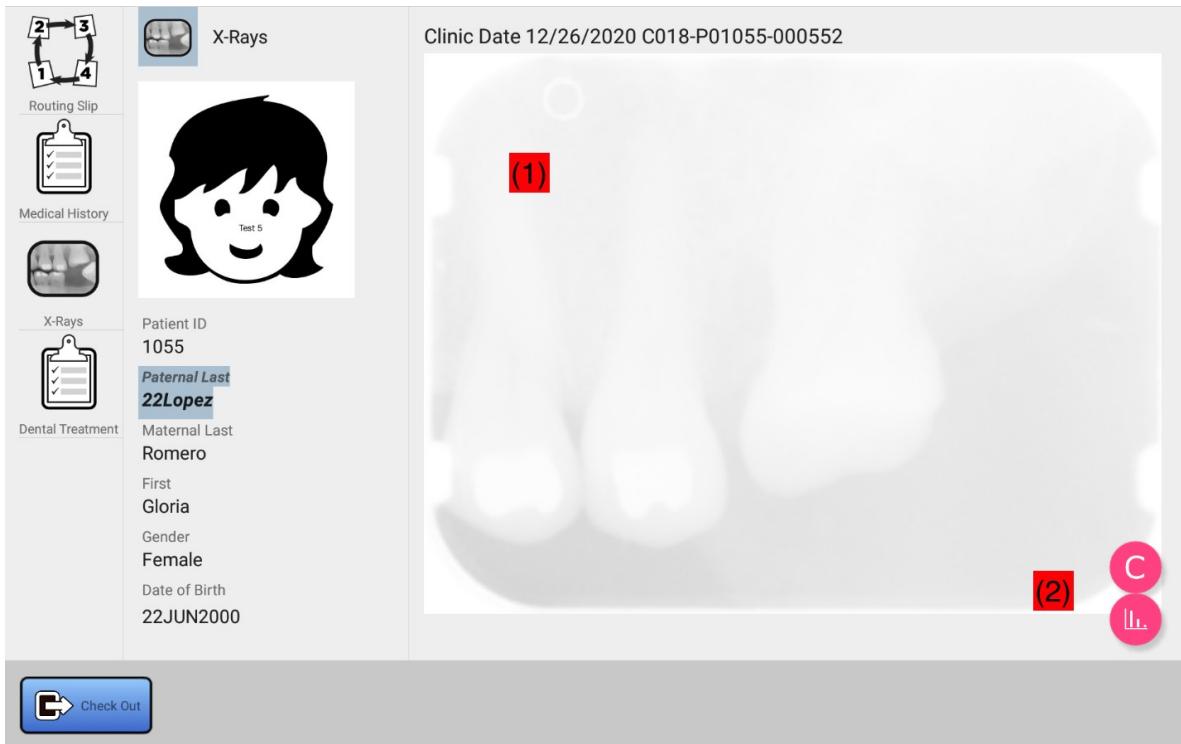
Viewing Selected X-Rays
